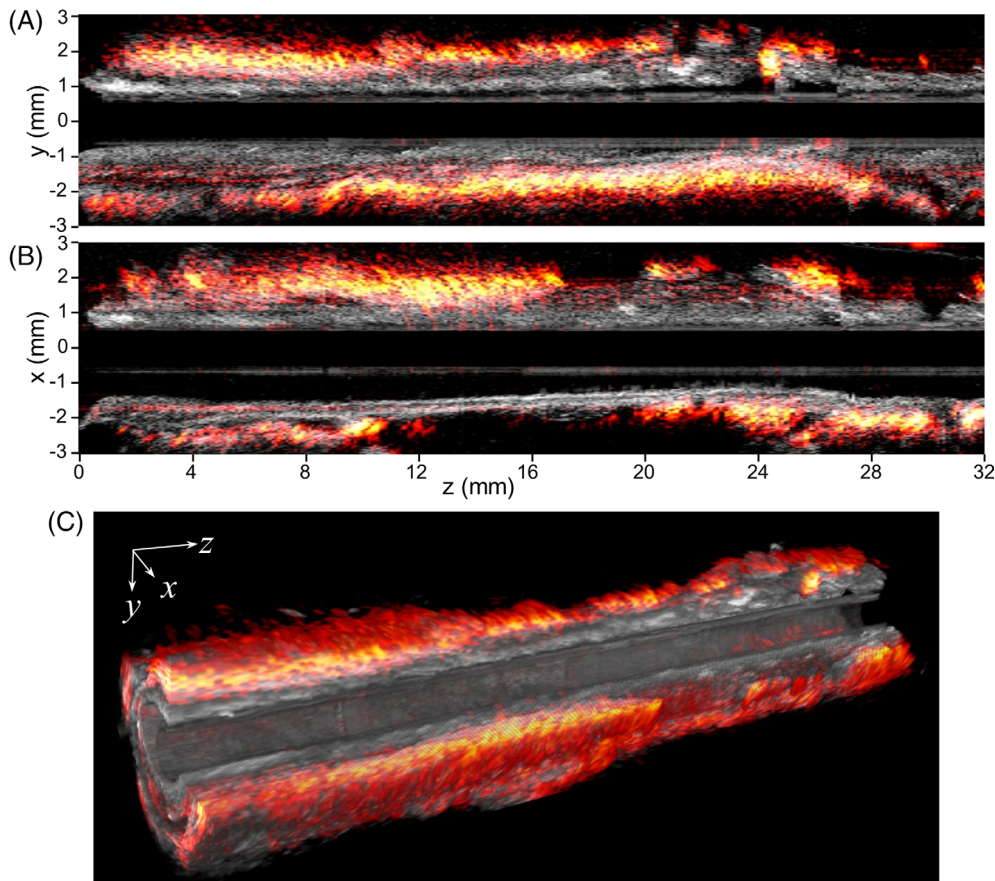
2D and 3D overlaid photoacoustic/ultrasound images over the pullback of the IVPA/US transducer through 32 mm length of artery. A, B, Overlaid photoacoustic/ultrasound images in yz and xz planes, respectively, C, 3D photoacoustic/ultrasound images of the artery with a 24 mm section length and a quarter cutaway for better visualization. IVPA/US, intravascular photoacoustic/ultrasound
